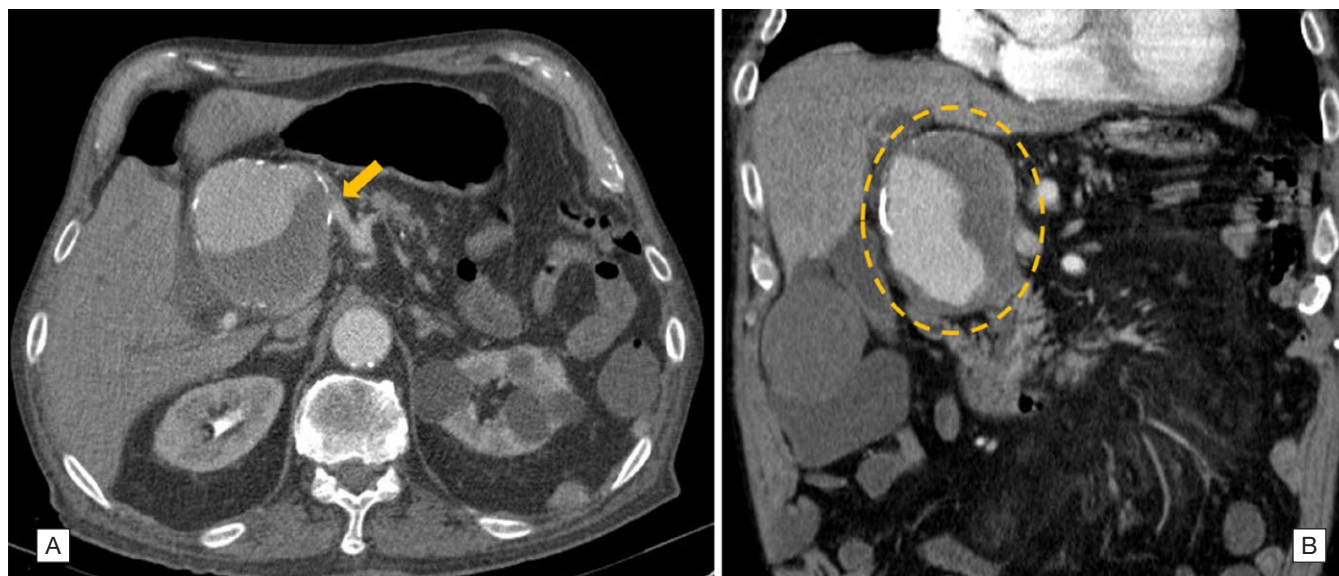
[A] - Axial computed tomography scan – saccular aneurysm originating from the gastroduodenal artery (arrow). [B] - Coronal computed tomography scan – gastroduodenal artery aneurysm with partial mural thrombosis.
